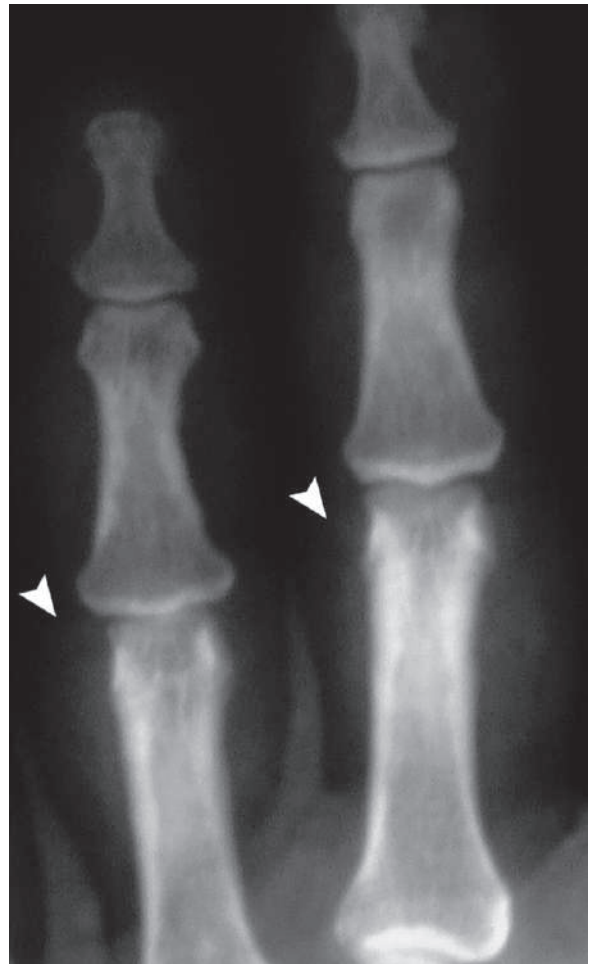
Plain radiograph of the fingers in a patient with psoriasis shows soft tissue swelling (*arrowheads*) of the PIP joints (*sausage fingers*)
